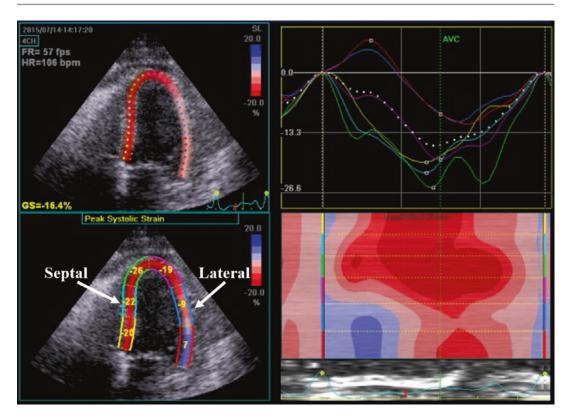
Apical 4-chamber view showing longitudinal systolic strain (speckle-tracking) in a patient with constrictive pericarditis. Lateral strain is prominently reduced
